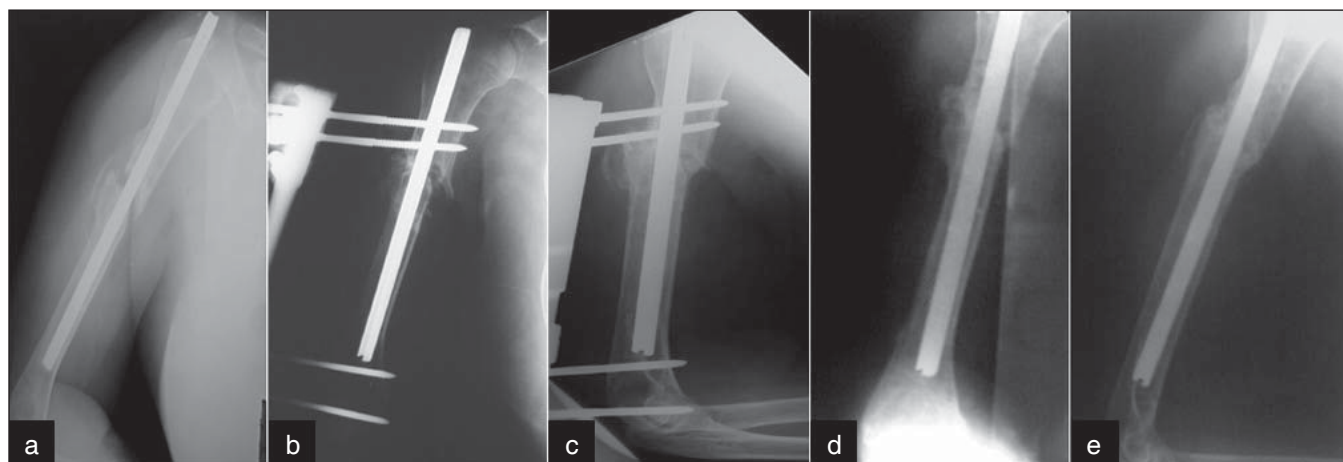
(a) Three years old nonunited fracture of upper third of the right humerus shaft in a 22-year-old female patient. The fracture was treated surgically by conventional Kuntscher nail fixation two times and one iliac crest bone graft (ICBG). Note the prominent nail causing limitation of shoulder abduction. (b, c) Postoperative radiographs show replacement of the Kuntscher nail with a shorter one, insertion of ICBG and application of orthofix limb reconstruction system (LRS). The nonunion was compressed to close the gap. (d, e) Follow-up radiographs show sound healing of the nonunion. The nail was left in place
